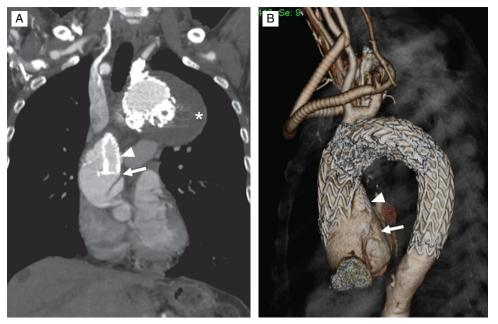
(A) Coronal CT scan at 20 days after endovascular aneurysm repair with a chimney graft. The asterisk indicates the almost completely thrombosed aneurysm sac, while the arrow indicates a new type A ascending aortic dissection. The arrow head indicates the chimney graft. (B) Three-dimensional image. CT: computed tomography
